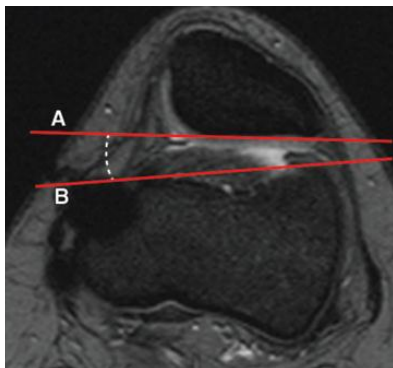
Lateral patello-femoral angle assessed on an axial T2-weighted fat-saturated MR image, which shows patellar tilt caused by rupture of medial ligaments in an 18-year-old woman. The patello-femoral angle (dashed line) is demonstrated as the angle between a line drawn along the lateral joint surface of the patella (line A) and a line drawn along the anterior aspect of the condyles (line B). A patello-femoral angle opening laterally is considered normal. An angle opening medially indicates patellar tilt.
